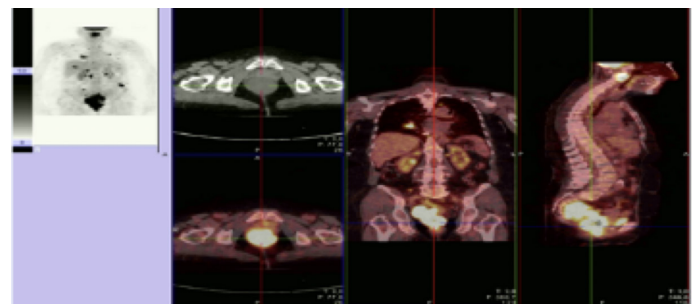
At the time of diagnosis PET CT images
